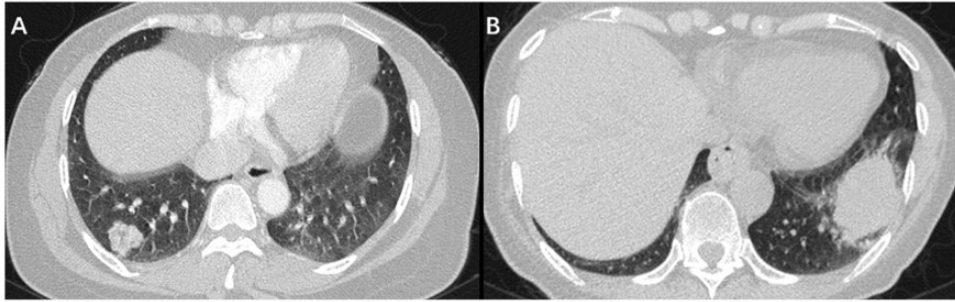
Typical imaging features of *ROS1*-positive and *ALK*-positive patients with non-small cell lung cancer: (a) A 49-year-old woman with adenocarcinoma. Computed tomography (CT) image showing a 2.2-cm non-solid nodule in the right lower lobe. *ROS1* rearrangement was detected by amplification-refractory mutation system (ARMS). (b) A 63-year-old woman with adenocarcinoma. CT image showing a 4.7-cm solid nodule in the left lower lobe. *ALK* rearrangement was detected by ARMS.
